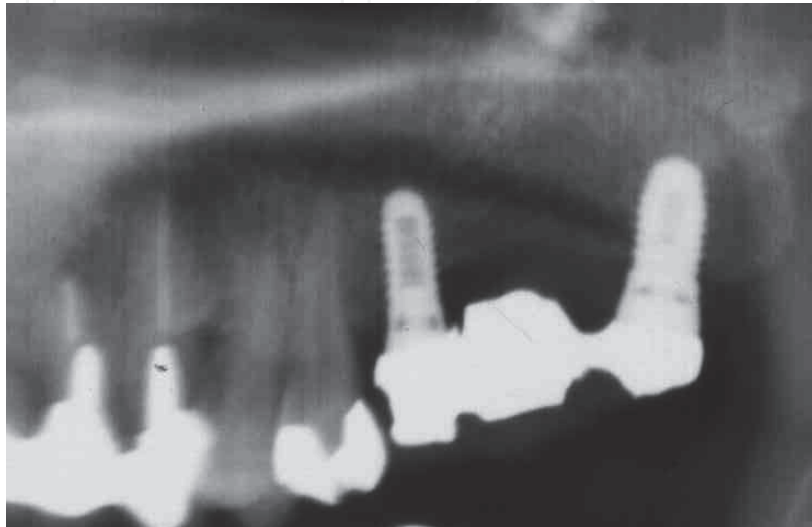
Radiograph showing slight bone resorption around the implants.
